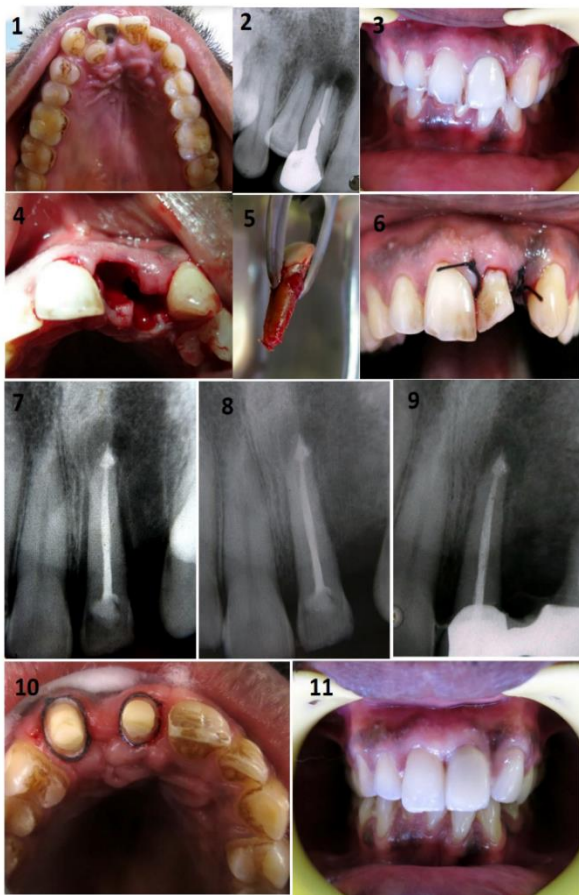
1) Preoperative photograph (occlusal view) 2) Preoperative intraoral periapical radiograph 3) Preoperative photograph (labial view) 4) Extraction of 21 and 22 was done 5) extracted 21 6) Autotransplantation done. Tooth stabilized with sutures. 7) One week follow up radiograph 8) Three months follow up radiograph 9) Nine months follow up radiograph 10) Tooth preparation done for porcelain fused metal crowns 11) Postoperative photograph after esthetic rehabilitation
